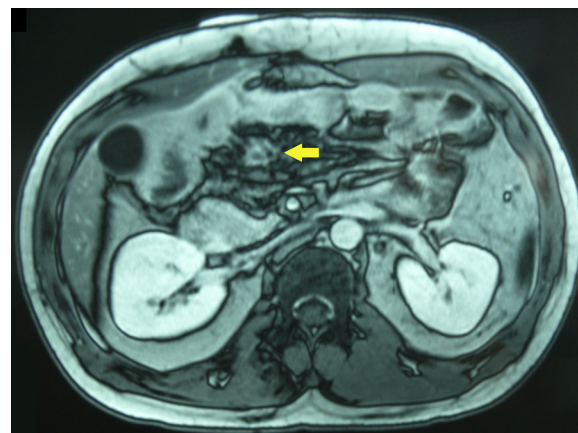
Magnetic resonance imaging performed after CT-guided percutaneous drainage. The abdominal mass had a smaller diameter (2.5 cm).
